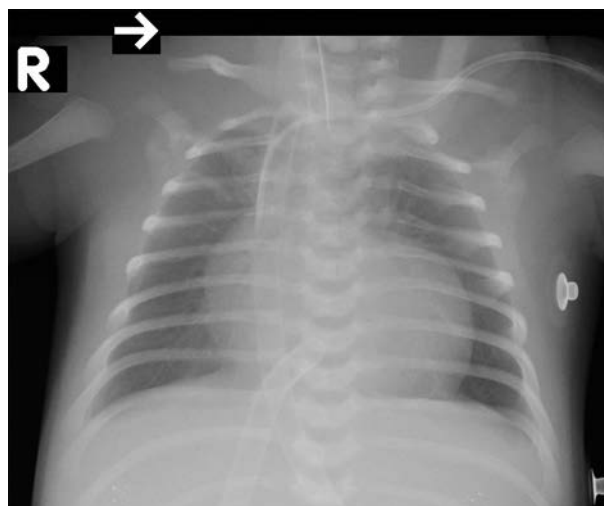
The first day after cardiac surgery (12th day of life). Chest radiograph shows an enlarged silhouette of the heart (however, the heart is significantly smaller than before the surgery); reduction in the transverse dimension of the heart; vascularity of the pulmonary fields is normal
